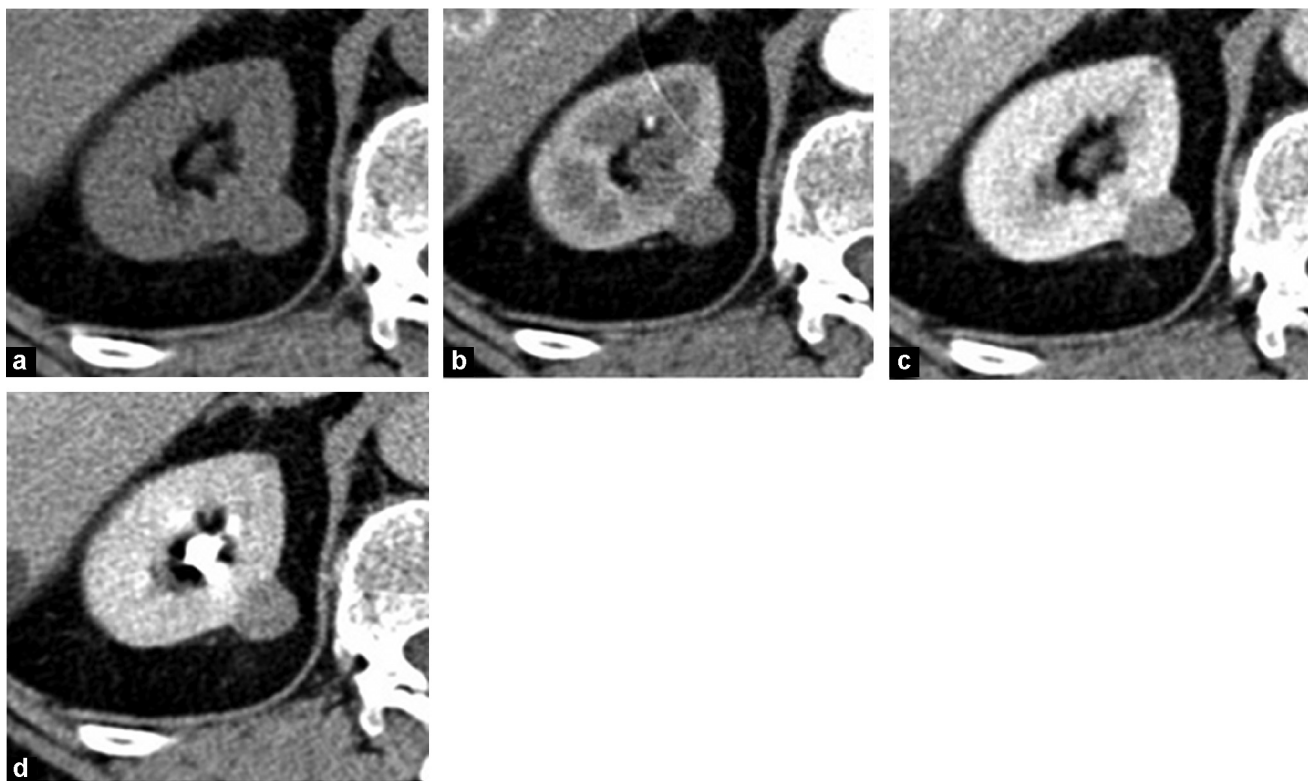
Small clearly demarcated, homogenous tumor enhancing weakly: typical CT appearance of papillary carcinoma; a: unenhanced (33 HU); b: arterial phase (38 HU); c: tubular phase (62 HU); d: delayed phase (66 HU).
